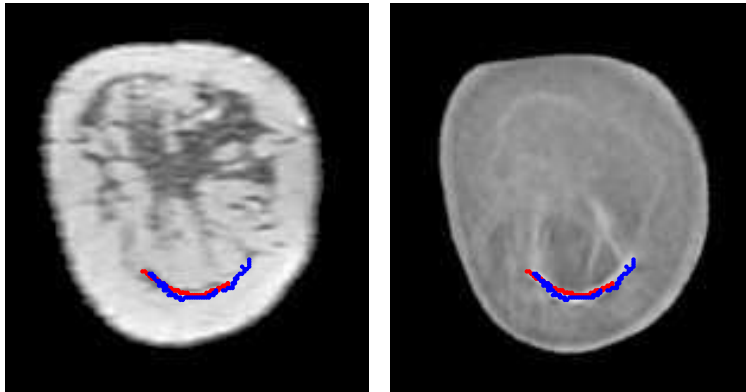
Result of the registration with strategy B. MRI (left) and USCT (right), each with markings of a connective tissue structure, which served as a basis for evaluation of the TRE. Blue denotes the surface points of the marking in USCT, red denotes the surface points of the marking in MRI. Note that both images show the same coronal slice from the 3D volumes.
